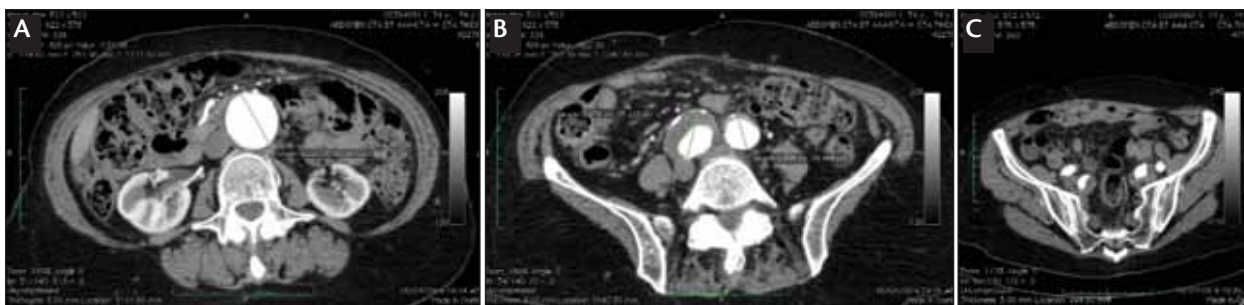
An aortic aneurysm scan demonstrated an infrarenal abdominal aortic aneurysm with a maximum anteroposterior diameter of 4.2 cm (A). An iliac artery aneurysm CT scan revealed that both common iliac arteries' origins were aneurysmal, with the right measuring 3.6 cm in maximum diameter and the left measuring 2.5 cm. (B). The internal iliac arteries were also aneurysmal, with the right measuring 2.1 cm in diameter. The external iliac arteries were normal, with minimal atherosclerotic disease (C).
